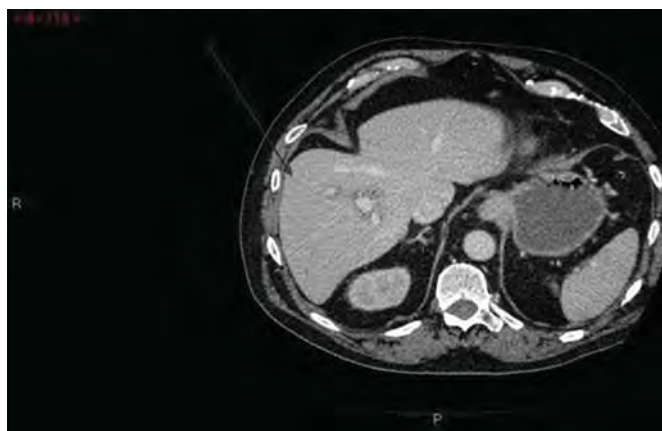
Normal liver staging CT.
